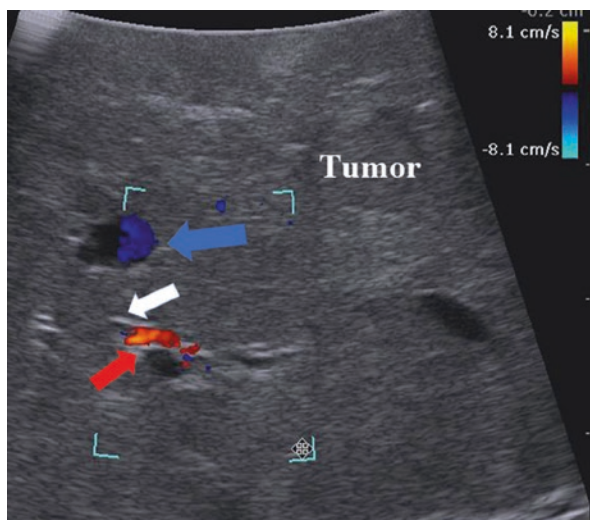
Laparoscopic ultrasonography demonstrating the detailed anatomical information of biliary (*white arrow*) duct, hepatic artery (*red arrow*) and hepatic vascular (*blue arrow*)
